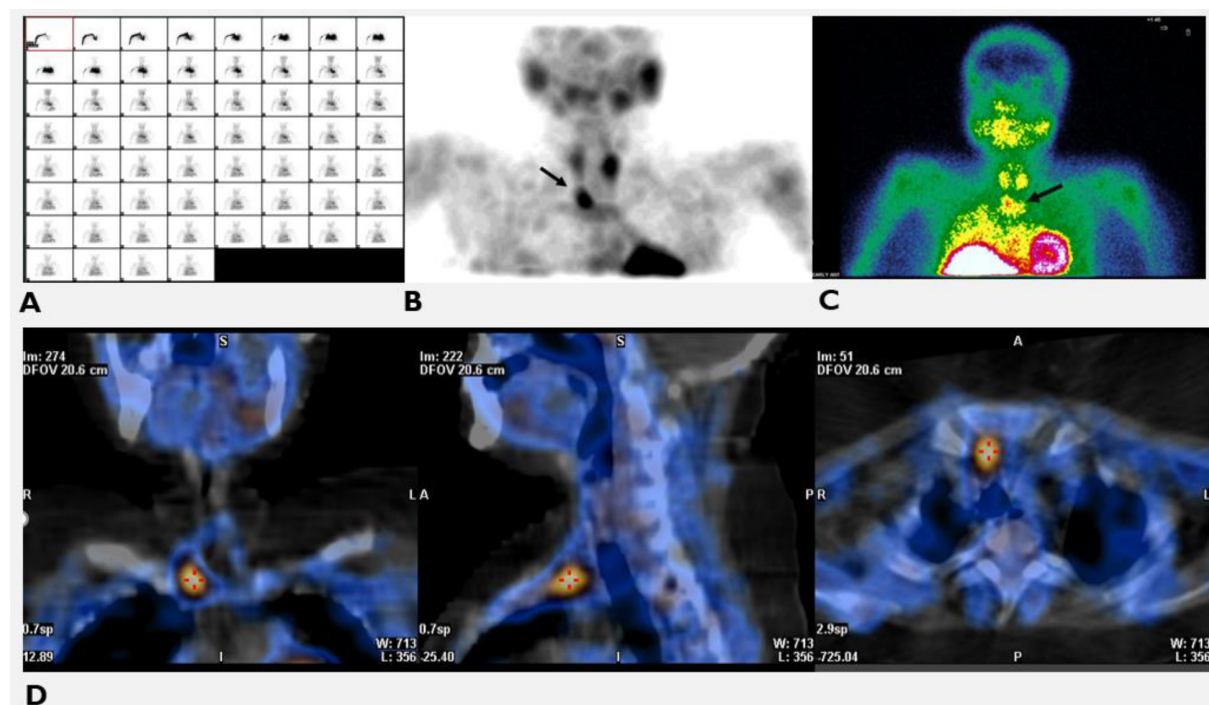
Perfusion images (A) demonstrate normal tracer flow in the neck. Early images (B) show physiological uptake in the thyroid gland with focal increased tracer uptake inferior to the right thyroid lobe (black arrow), which persists on delayed images despite thyroid washout. The Maximum intensity projection (MIP) image (C) localizes the lesion inferior to the right thyroid lobe (the black arrow). Single-photon emission computed tomography/computed tomography (SPECT/CT) images (D) of the neck and thorax reveal an ill-defined soft tissue lesion with focal tracer uptake posterior to the right sternoclavicular joint (red crosshair). These findings are suggestive of an ectopic parathyroid adenoma.
